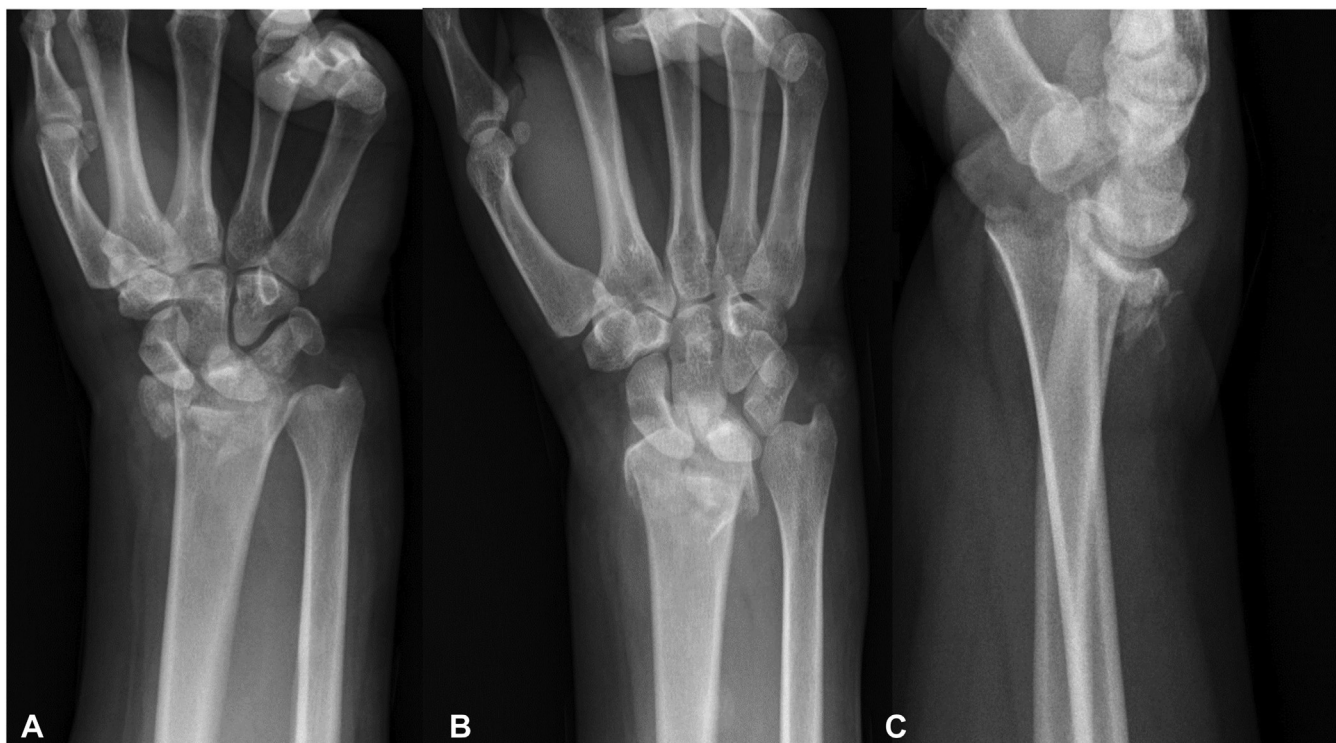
Representative A posteroanterior, B oblique, and C lateral radiographs of an intra-articular DRF.
